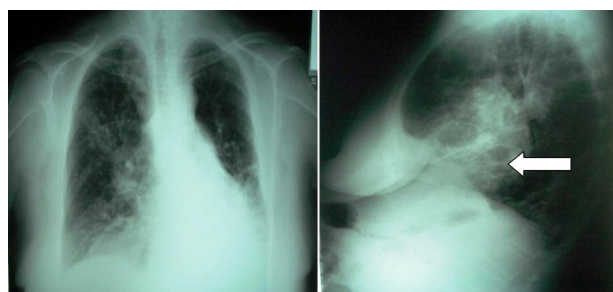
Posteroanterior and lateral chest radiographs demonstrating prominent lung markings and interstitial thickening, as well as volume loss, which is more evident in the left lower lobe and right upper lobe. Bronchiectases are more obvious in the lateral radiograph.
